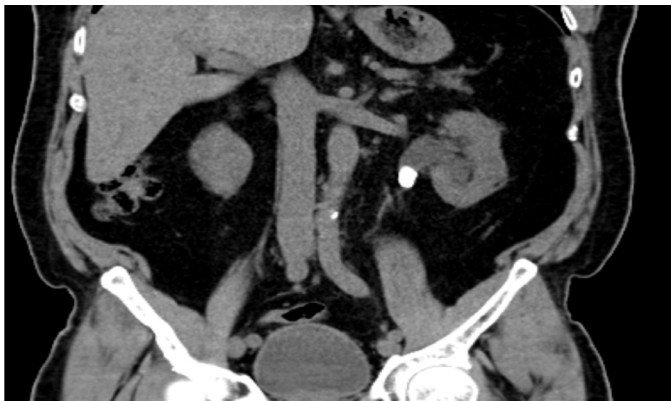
Pre-operative CT of 1.9 cm left upper uretral stone with grade 3 hydronephrosis
